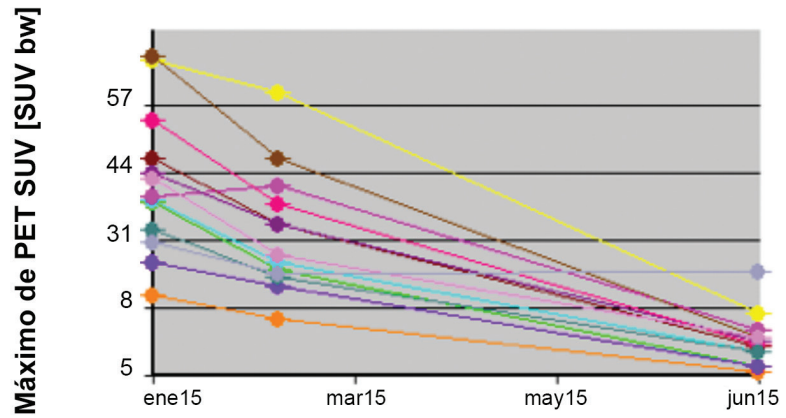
SUV max, behavior following 4 doses of treatment using 223Ra
